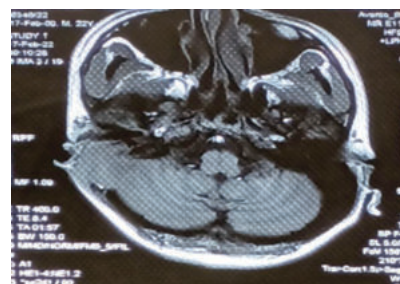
T1 MRI showing iso to hypointense lesion in right mastoid
